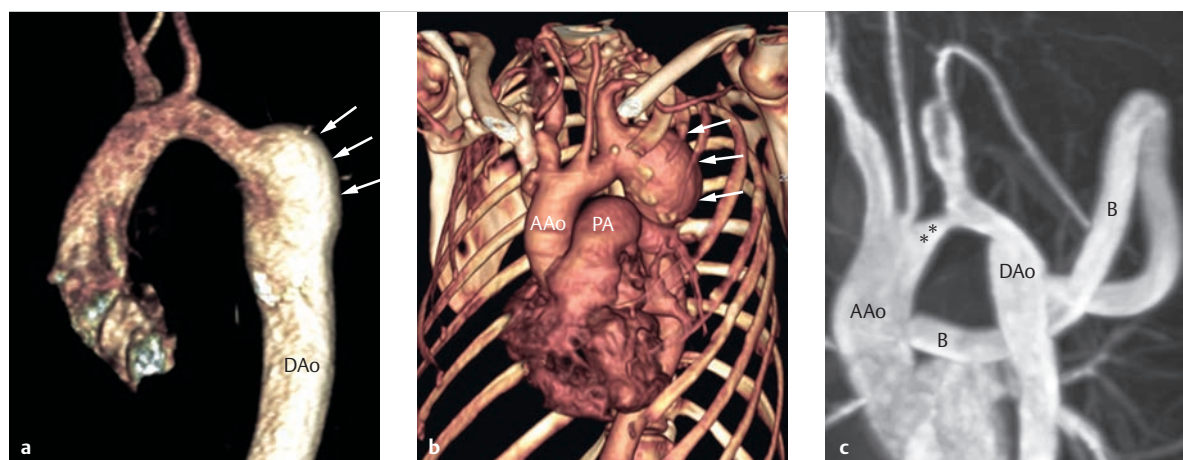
Formation of an aneurysm after a Vosschulte patch aortoplasty. Depiction of the thoracic aorta of three different patients after placing an indirect aortoplasty patch made of foreign materials (Vosschulte patch aortoplasty). The 3-D volume rendering of a contrast-enhanced MRA (a), like the 3-D volume rendering of a CTA (b), shows a typical complication of this surgical technique, namely the development of an aneurysm (a, b, arrows) near the patch aortoplasty. In addition to the patient's condition after a Vosschulte patch aortoplasty, the 3-D MIP reconstruction of an MRA still depicts a hypoplastic aortic arch (c, double asterisk). For this reason, an extra-anatomical bypass of the ascending aorta was attached to the descending aorta, without any relevant residual restenoses or aneurysm formation.
